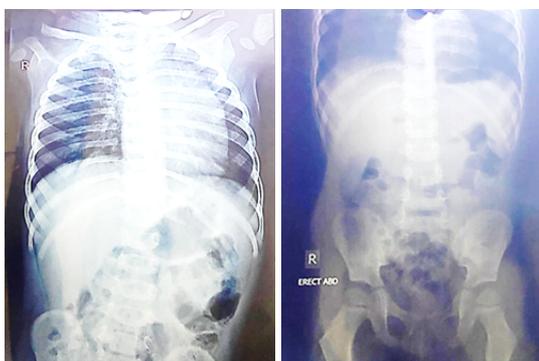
X-Ray Report of hyperinflation characteristic of asthma
